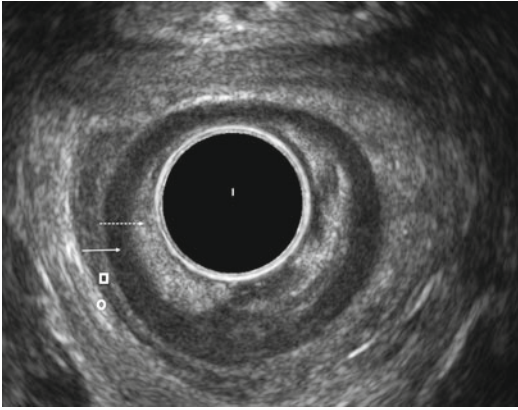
Endoanal ultrasound demonstrating normal sphincter anatomy. Subepithelium (*dotted arrow*) and internal anal sphincter (*thin arrow*). The longitudinal muscle (*square*) and external anal sphincter (*circle*) with comparable reflectivity are distinguished by their interface reflections
